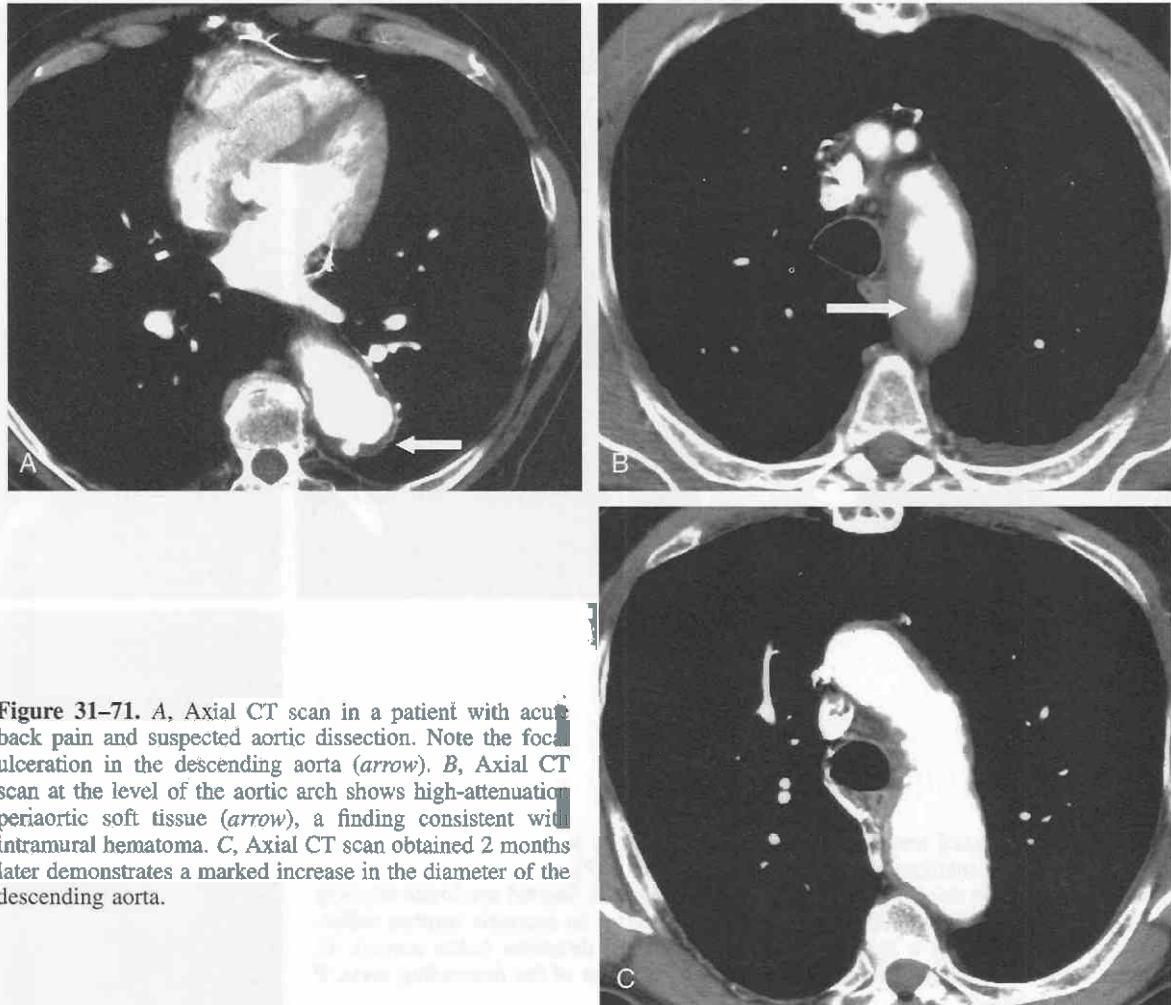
A, Axial CT scan in a patient with acute back pain and suspected aortic dissection. Note the focal ulceration in the descending aorta (*arrow*). B, Axial CT scan at the level of the aortic arch shows high-attenuation periaortic soft tissue (*arrow*), a finding consistent with intramural hematoma. C, Axial CT scan obtained 2 months later demonstrates a marked increase in the diameter of the descending aorta.
